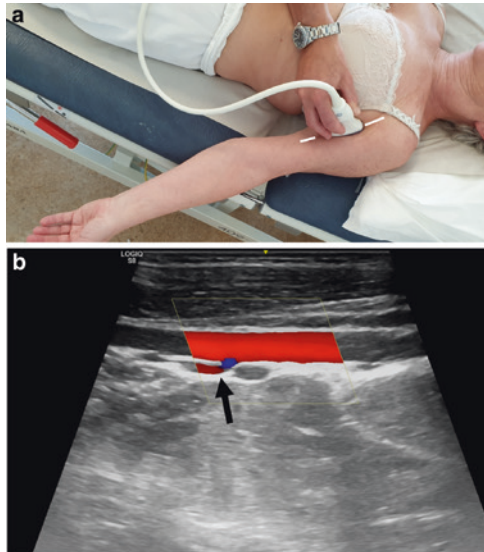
Examination of the distal axillary artery: a recommended transducer position, anteromedial approach b ultrasonographic view of the distal axillary and brachial artery (including the deep brachial artery-black arrow)
